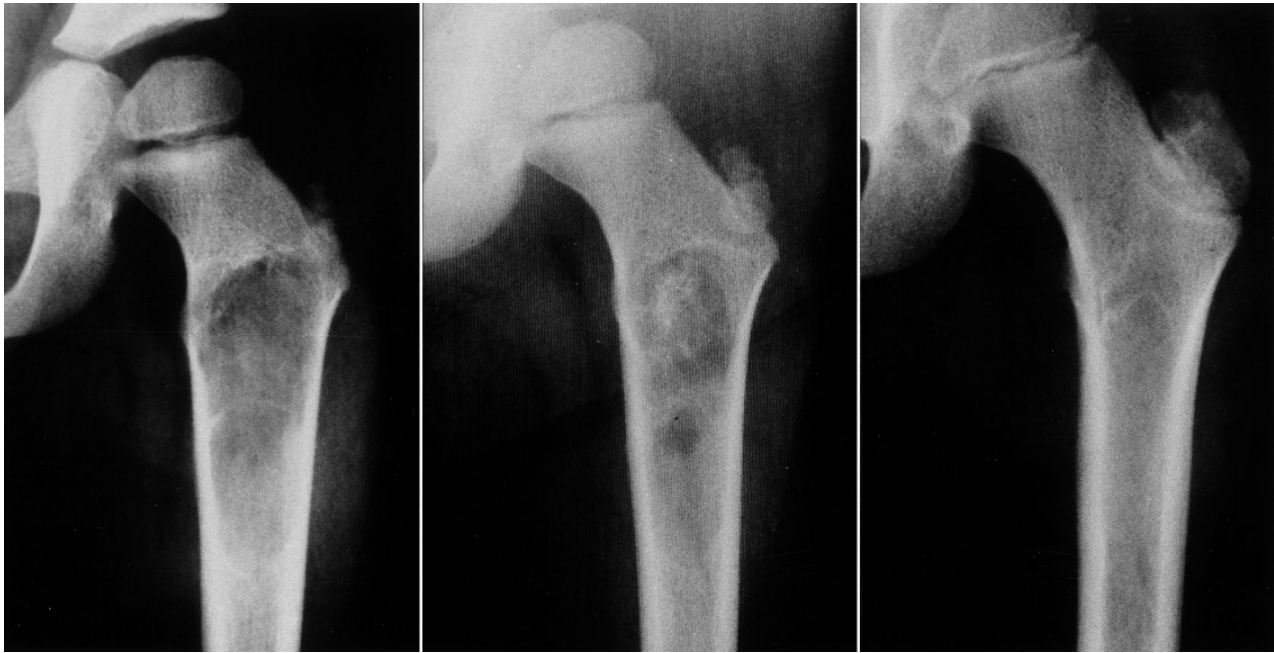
Progressive healing of a simple bone cyst in the proximal femur in a 5-year-old girl (case 6). Postoperative radiographs at 1, 7 and 26 months
